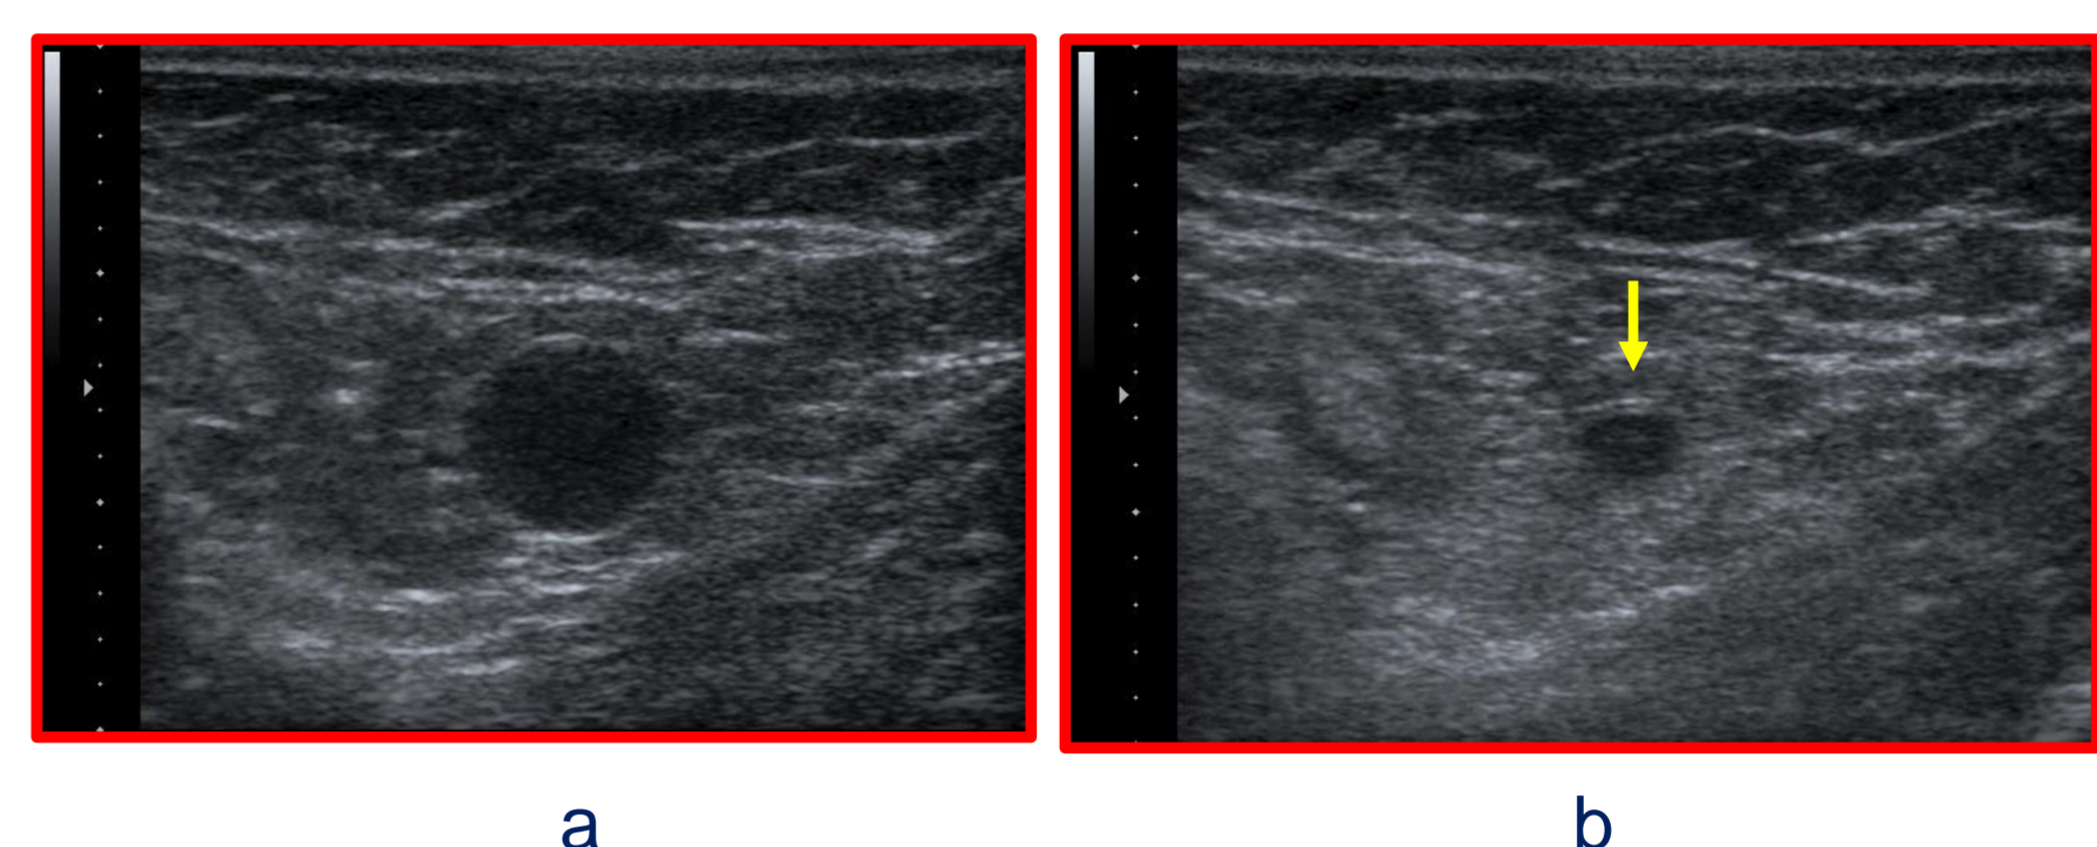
Ultrasound comparison of adjacent GSV segments with pre-treatment diameter of 8.2–8.7 mm, week 8 after ClosureFast, a) using tumescent anesthesia, b) after hyaluronan compression
